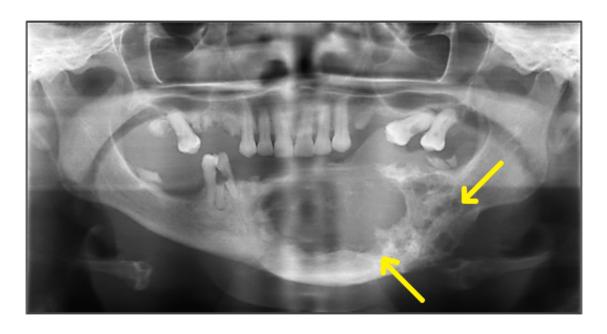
Orthopantomogram showing an image of a large radiolucent zone in the left symphysis-parasymphysis, and polygeodic osteocondensing zones posteriorly with basilar rim involvement.
